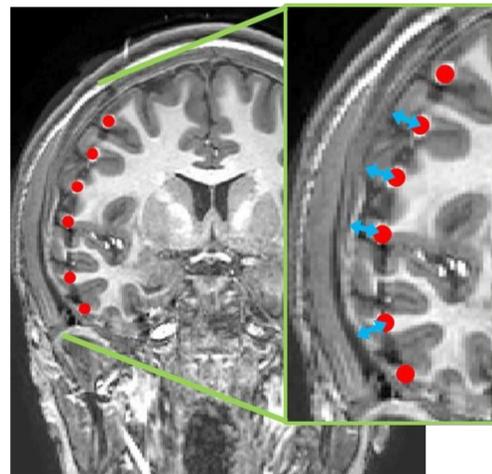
Example of brain shift colocalization from postoperative CT with electrodes overlaid on preoperative T1 MRI
